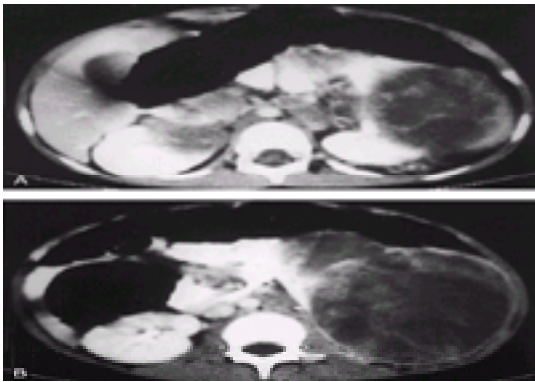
A. Bilateral Wilms' tumor. A 5-year-old girl with left flank mass. Computed tomographic (CT) sections of the upper abdomen with contrast medium enhancement show a necrotic mass arising from superior aspect of the left kidney. Note a small mass in the superior medial aspect of the right kidney. B. Bilateral Wilms' tumor (same patient as in A) CT section of the abdomen with contrast medium enhancement shows extent of the large necrotic left Wilms' tumor with periaortic adenopathy.
